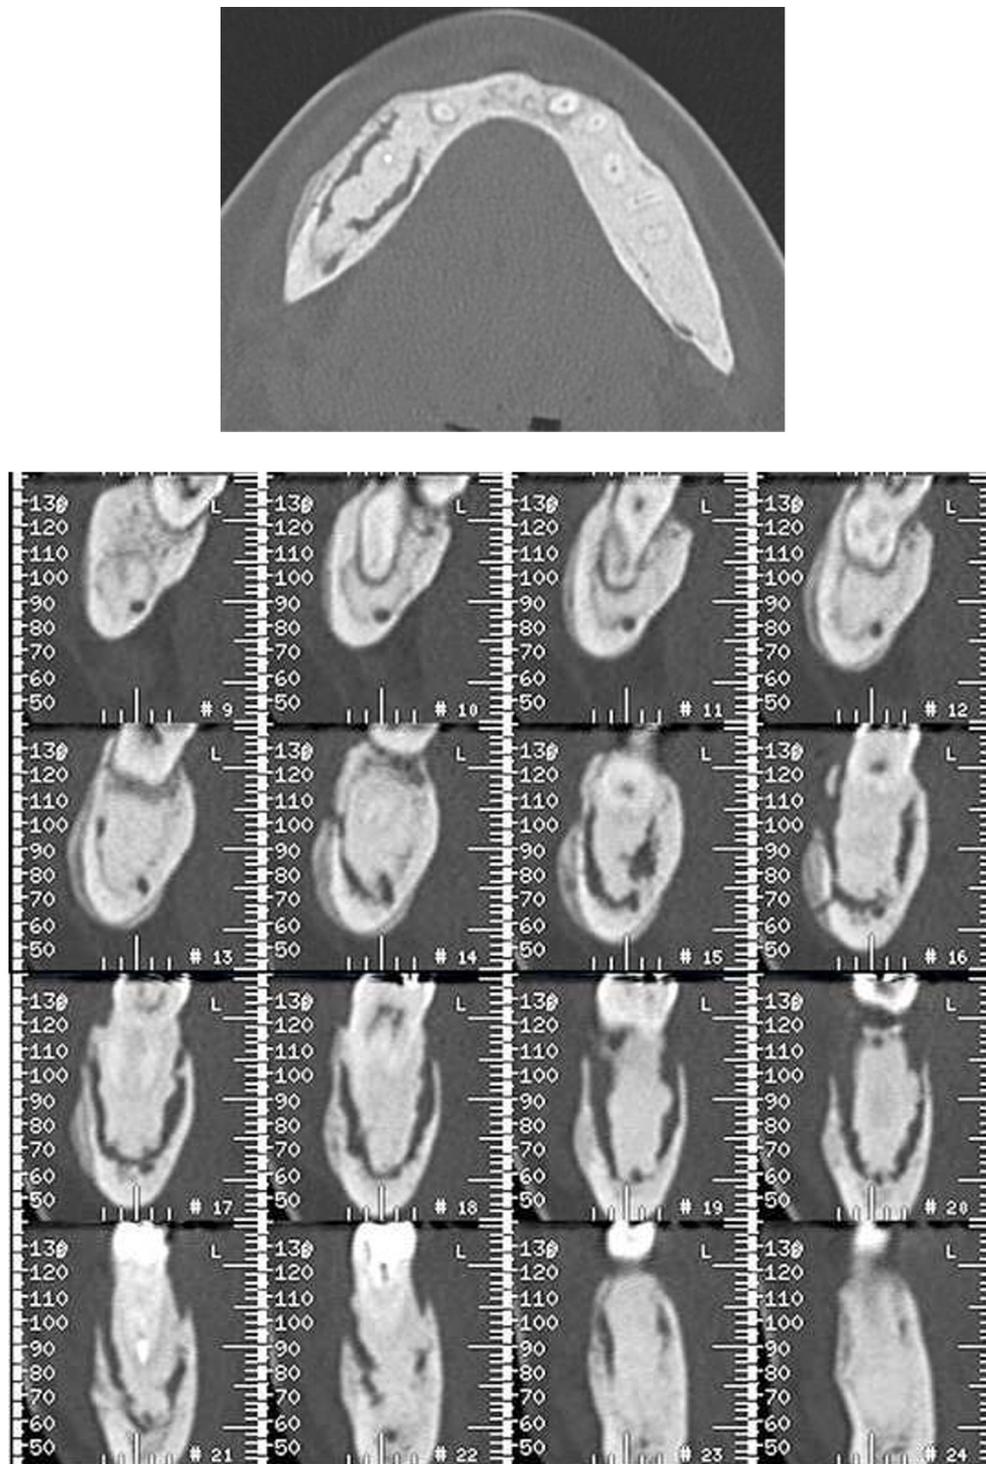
Case 2. Preoperative maxillofacial CT, with sagittal (4a) and frontal (4b) views, demonstrating a right mandibular osteolysis.
